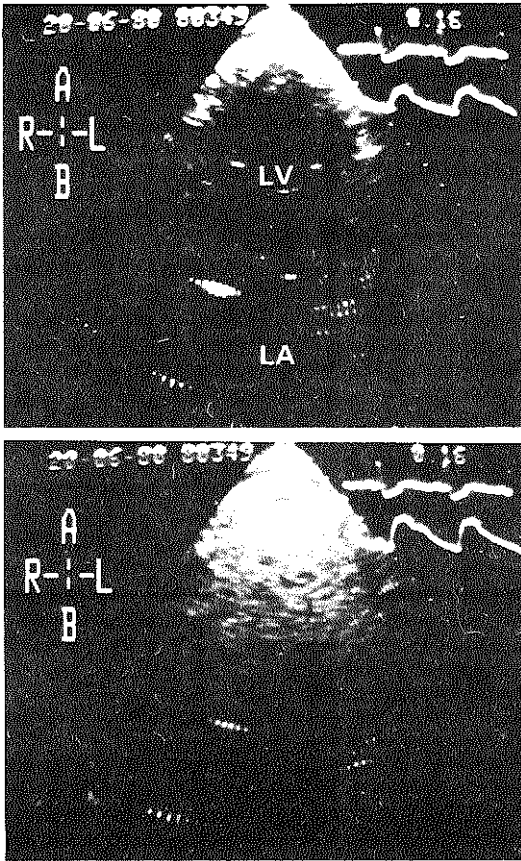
Stop-frame images of apical four-chamber views obtained from a patient with a dilated left ventricle before (upper panel) and after (lower panel) catheter injection of echo contrast in the left ventricle (LV). The left atrium remains echo free, which excludes mitral insufficiency. Border recognition is not facilitated after its opacification.
